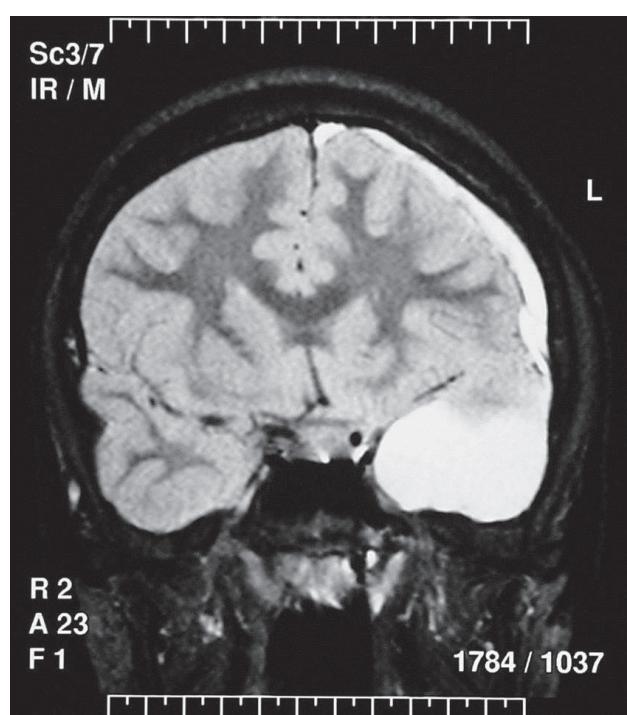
MRI FLAIR sequence in the coronal plane.
